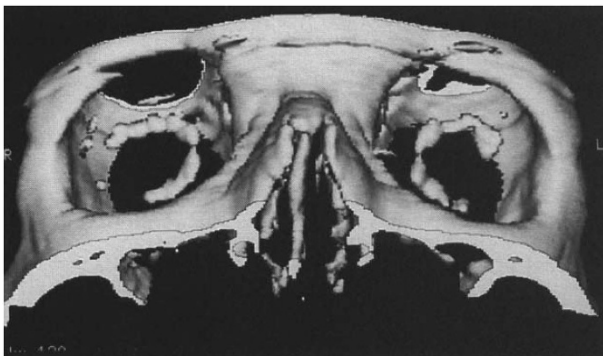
3D CT reformatted image of lesions of the orbits showing the distribution of the calcification (in the region of 500 Hounsfield units).
